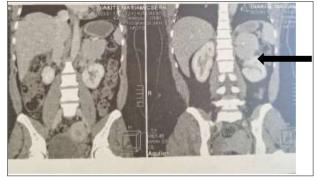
Abdominal CT scan of a frontal section showing a left adrenal tumour.
